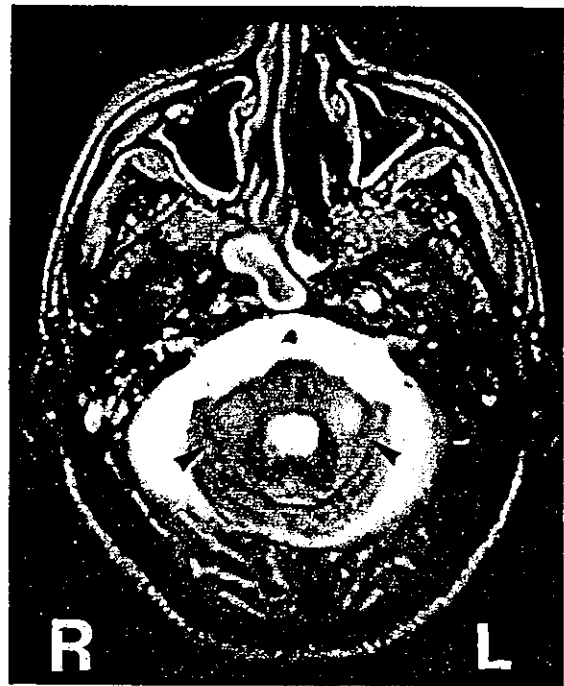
Cranial MRI showing bilateral lesions of the middle cerebellar peduncles as a high signal intensity on the T2-weighted image (arrowheads).
